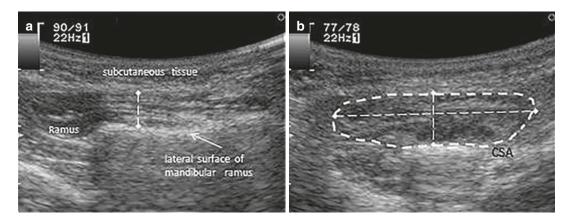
Transverse ultrasound image of (a) relaxed and (b) contracted left masseter muscle demonstrating the measurement of length (horizontal dotted line), thickness (vertical dotted lines), and cross-sectional area (CSA)
